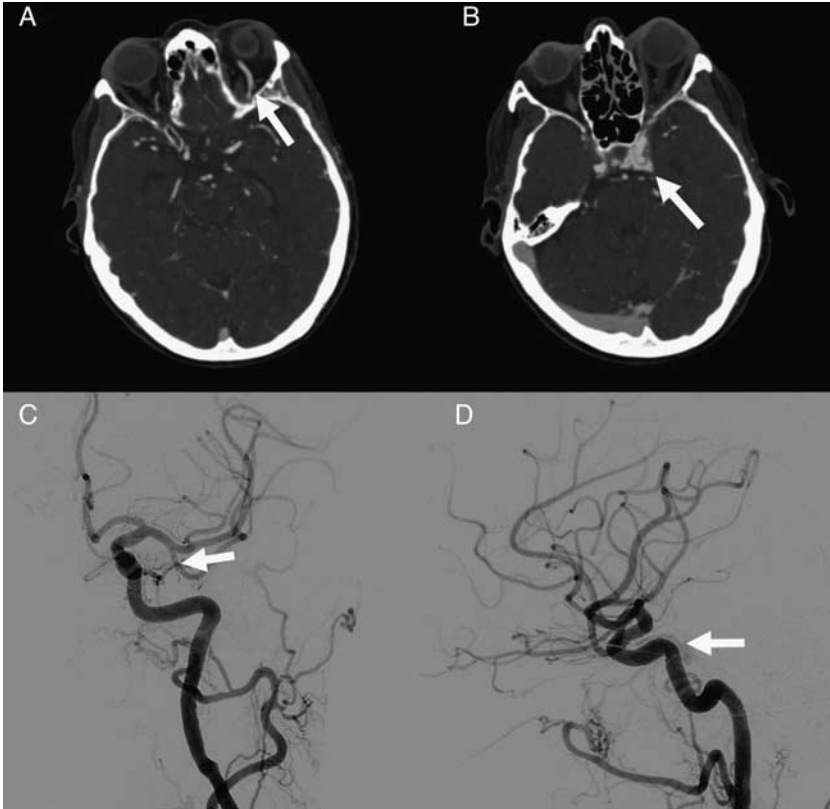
84-year-old woman presented with progressive left chemosis, proptosis, and elevated intraocular pressure for 2 months. Axial CT angiogram through the orbits demonstrates hyperenhancement and dilation of the left superior ophthalmic vein (A, white arrow). CT angiogram in the same patient at the level of the cavernous sinus demonstrates hyperenhancement and enlargement of the left cavernous sinus (B, white arrow). Anteroposterior and lateral views of left internal carotid artery digital subtraction angiogram demonstrates abnormal filling of the ipsilateral venous sinus (C and D, white arrows). There was evidence of filling from the internal and external carotid arteries consistent with type D carotid cavernous fistula. CT indicates computed tomography.
